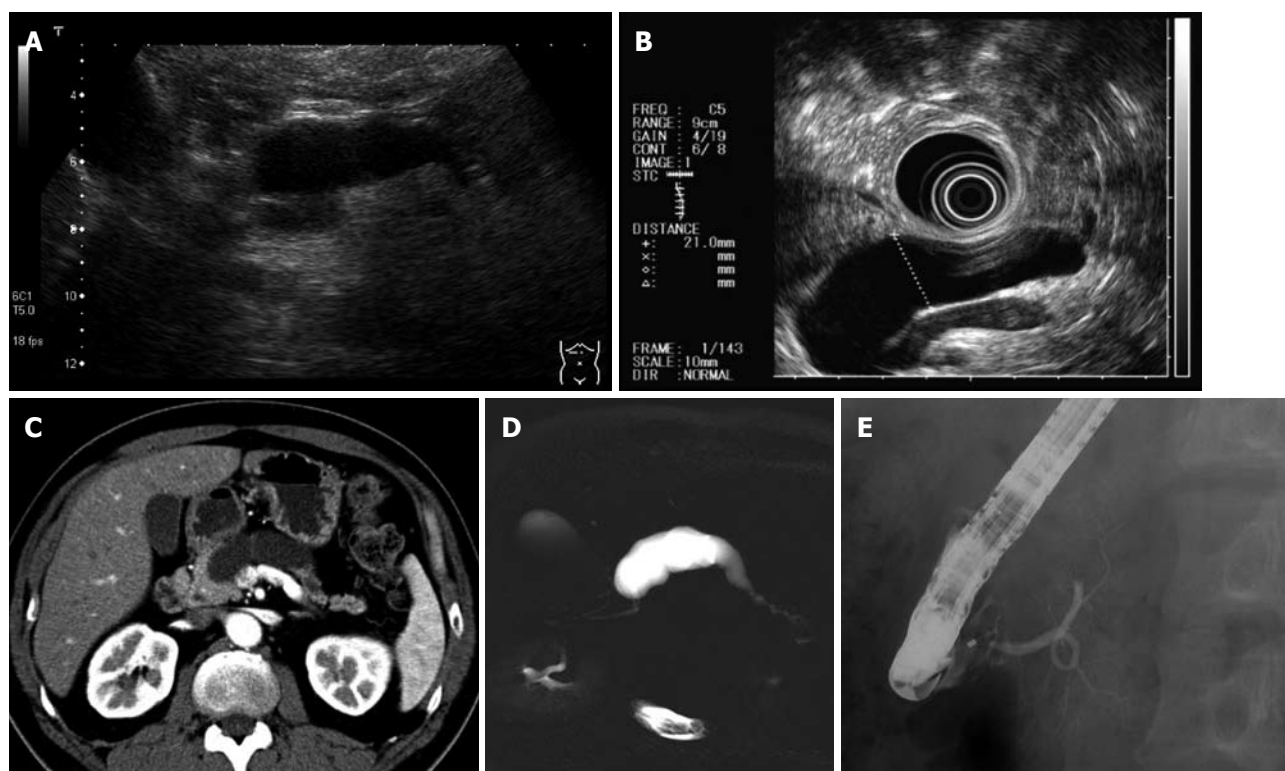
No tumor was detected by endoscopic ultrasonography, computed tomography and magnetic resonance imaging. The diameter of the main pancreatic duct was > 20 mm at the body. A: Ultrasonography; B: Endoscopic ultrasonography; C: Computed tomography; D: Magnetic resonance cholangiopancreatography; E: Endoscopic retrograde pancreatography.
